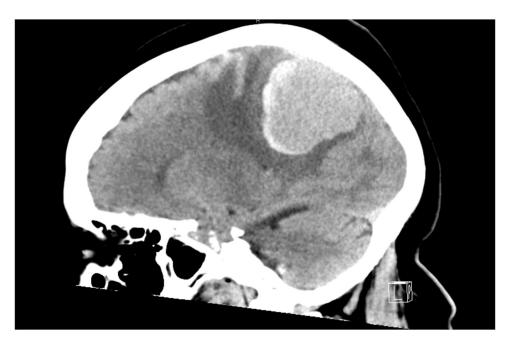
Computed tomography (CT) scan of the brain in sagittal view revealing a dural-based right parietal hyperdense mass with surrounding edema, mass effect and compression of the right lateral ventricle's atrium.
